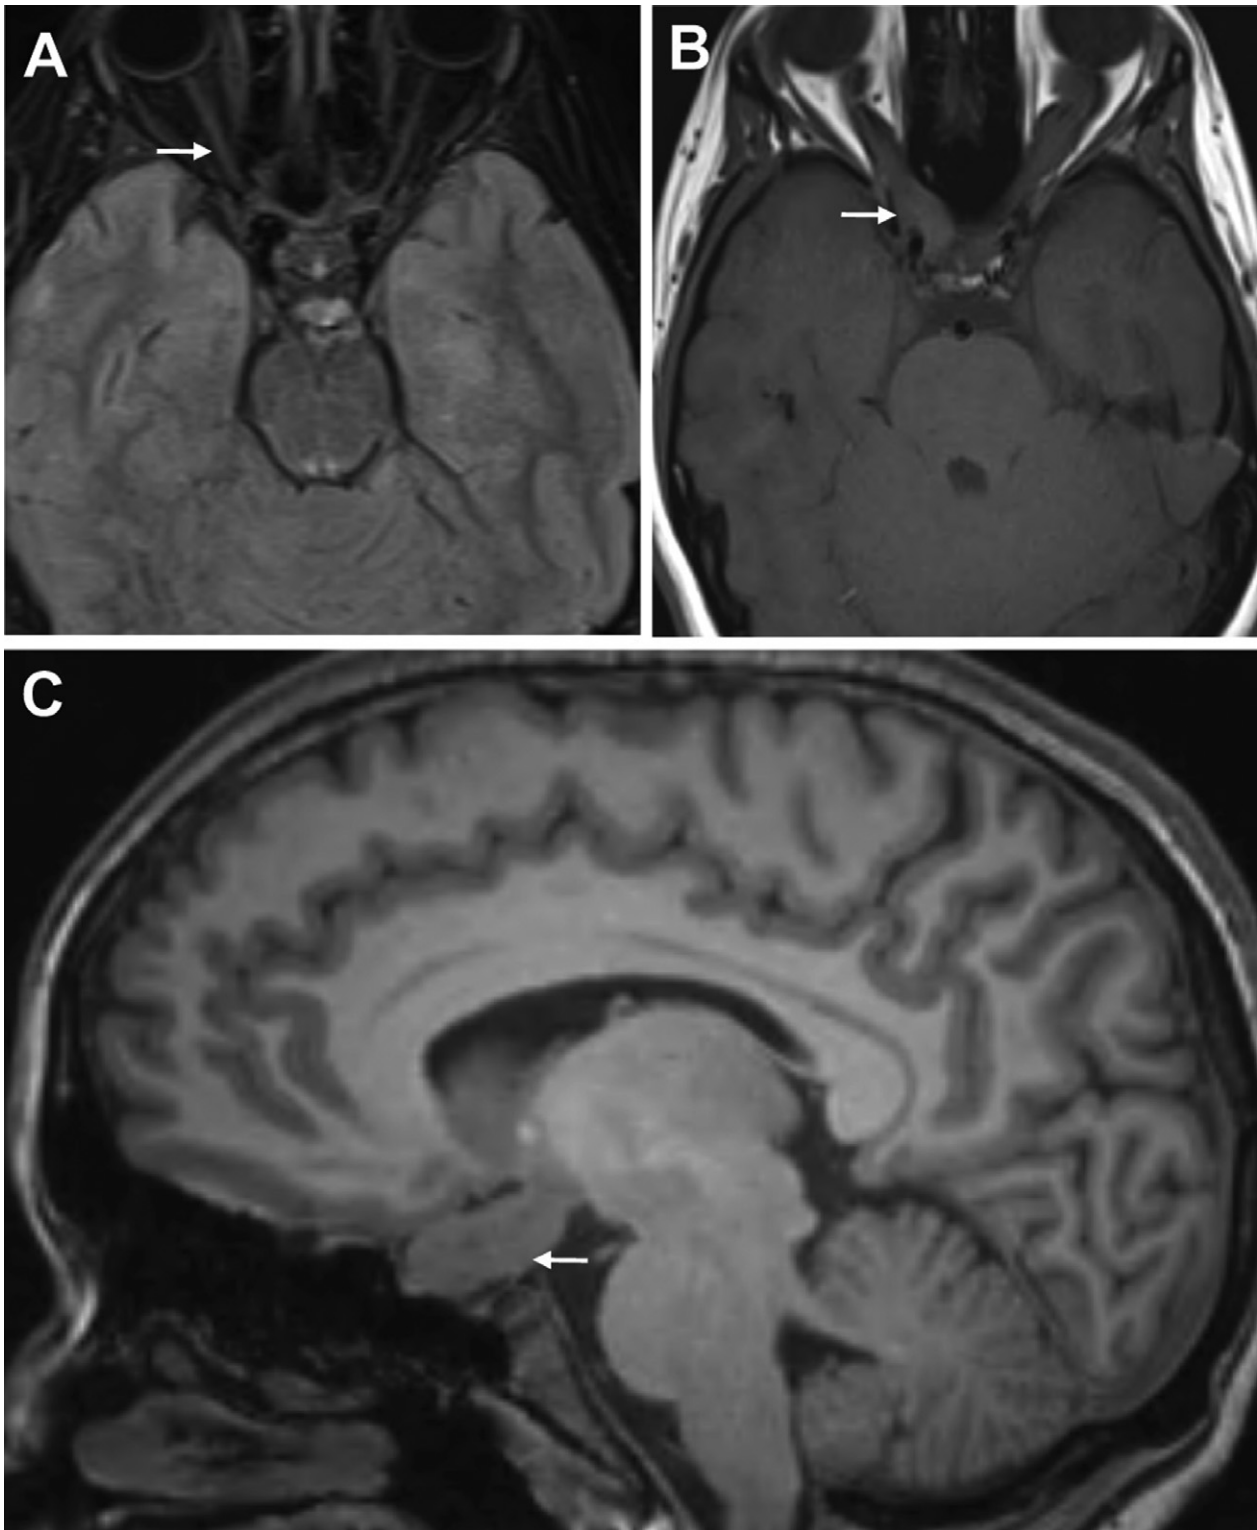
Neurofibromatosis type 1-associated optic glioma. (A) A representative normal optic nerve (child without an optic glioma) is shown by axial magnetic resonance imaging (arrow). (B) Fusiform enlargement of the optic nerve is evident in a child with a large right optic pathway glioma (arrow). (C) The extent of the optic pathway glioma, which includes the optic chiasm, is shown on the sagittal magnetic resonance image (arrow).
